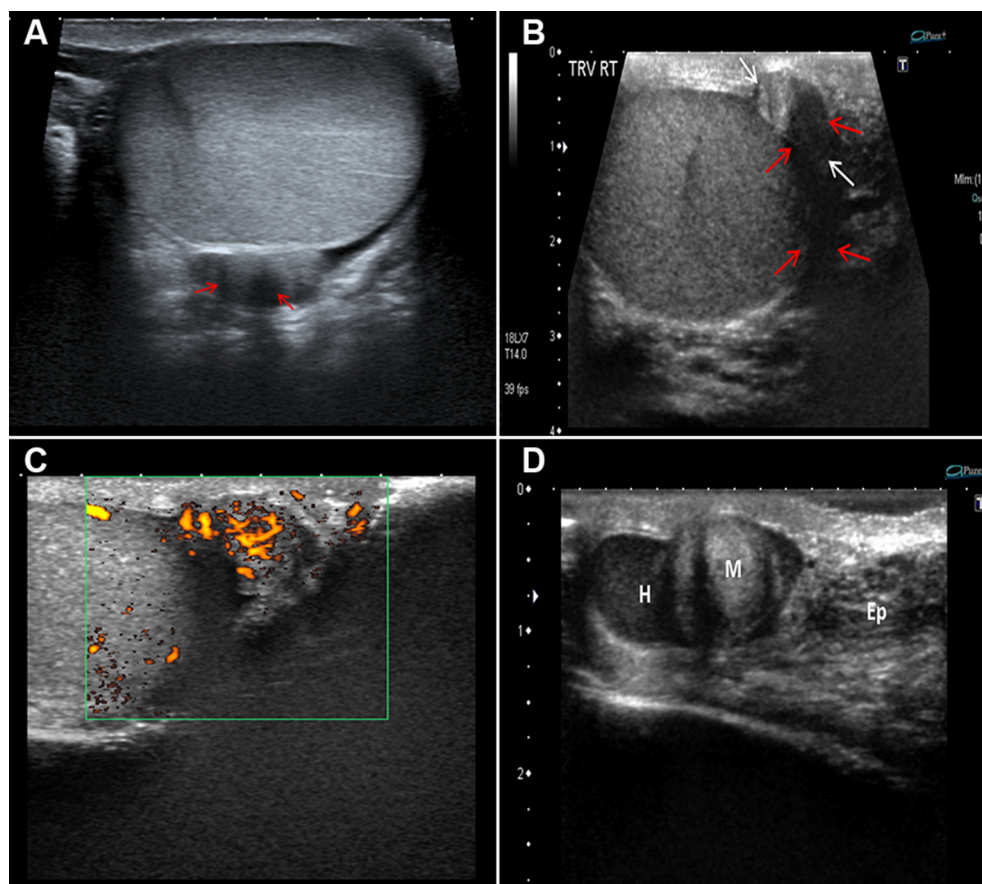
(A) Transverse sonogram shows an oval, iso-hypoechoic soft tissue nodule posterior to the right testicle. The nodule has poorly-demarcated areas of distal shadowing in keeping with dense fibrous stromal component (red arrows). (B) The mass is well-demarcated from the testicle (white arrows). Shadowing fibrous component obscures part of the mass and testicle (red arrows). (C) Doppler demonstrates vascularity within the mass. (D) Paratesticular mass with whorled pattern (M), epididymal tail (Ep) and hemocele (H).
